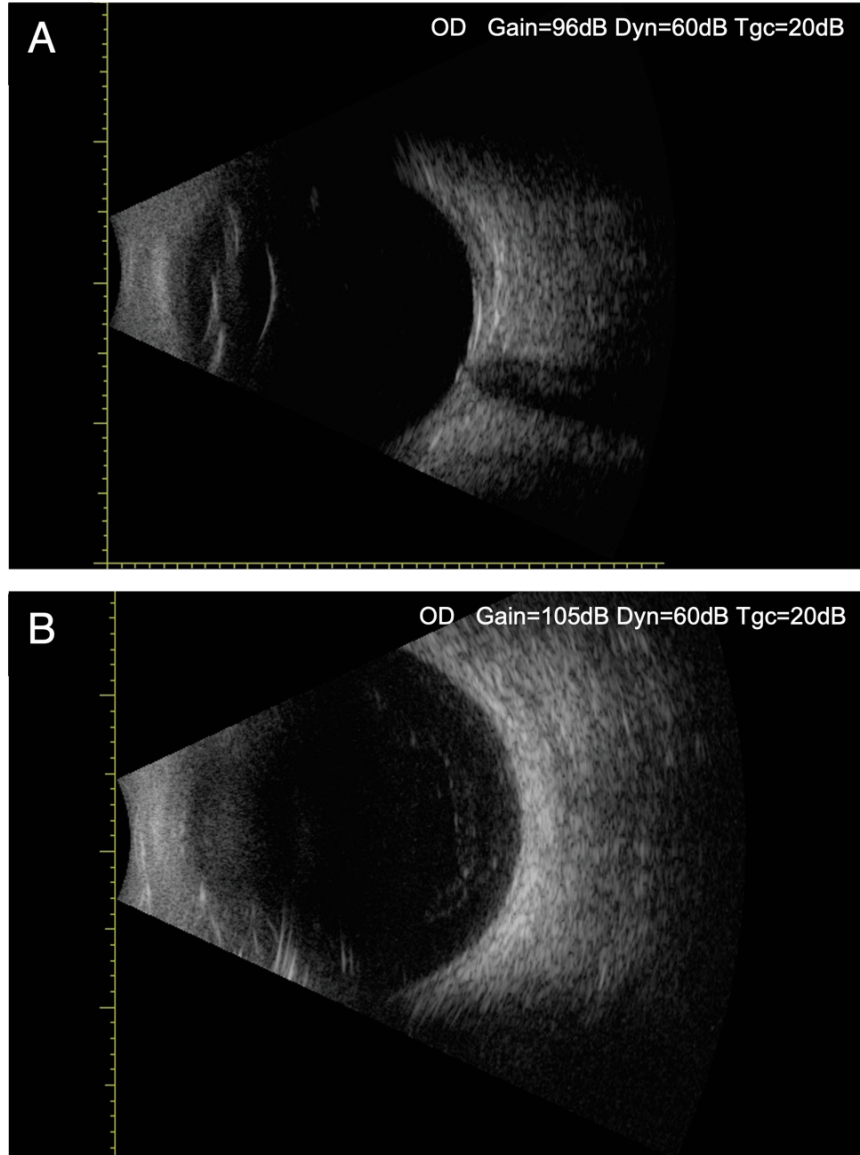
Postoperative B-scan ultrasonography of patient 2. B-scan ultrasonography results of patient 2 on 6 months (A) and 9 months (B) post-injection showed no remarkable changes in the vitreous body.
